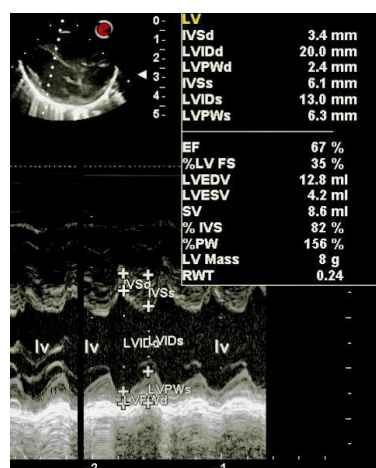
M-mode Echocardiography. LV volumetric estimation.
